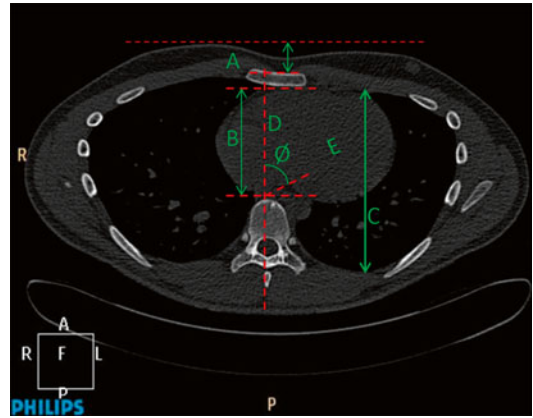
Chest CT Scan showing measurements to calculate the depth of sternal depression (*A*), Sternal Depression Index (*C/B*), and cardiac rotation angle (\emptyset). *D*=sagittal line from anterior border of the vertebral body and line from anterior border of vertebral body (*E*)
